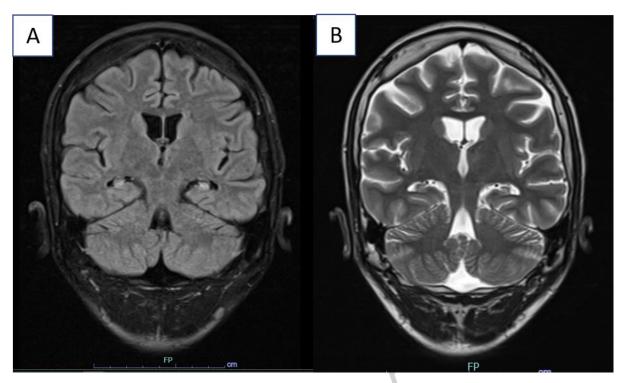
MRI brain (A) Flair, (B) T2 that both showed evidence of bilateral hippocampal atrophy and mesial temporal sclerosis.
